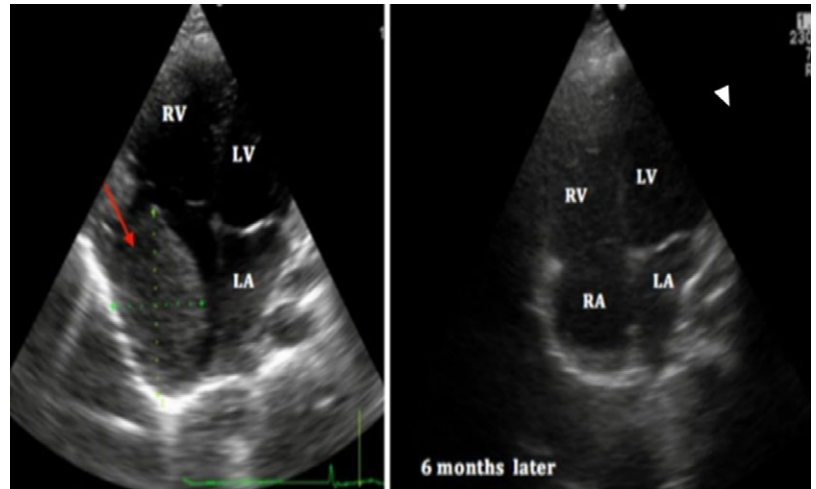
2D transthoracic echocardiogram, apical four-chamber view, demonstrating giant mass into the right atrium (arrow), left atrium (LA), right atrium (RA), right ventricle (RV), left ventricle (LV).
